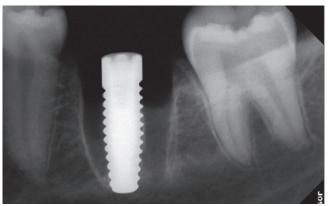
X-ray image of the implant region 36.
